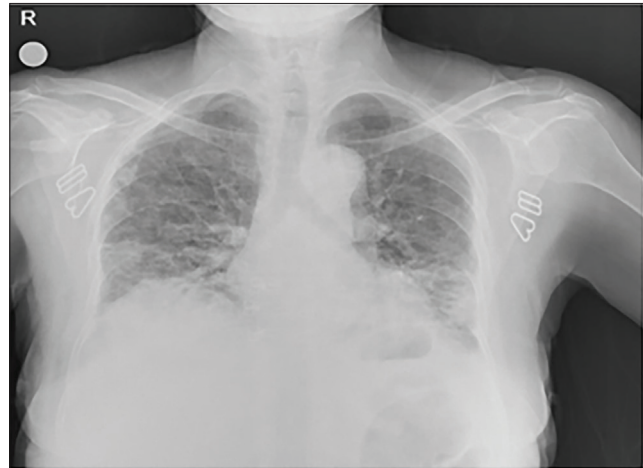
Chest X-ray before plasmapheresis.
